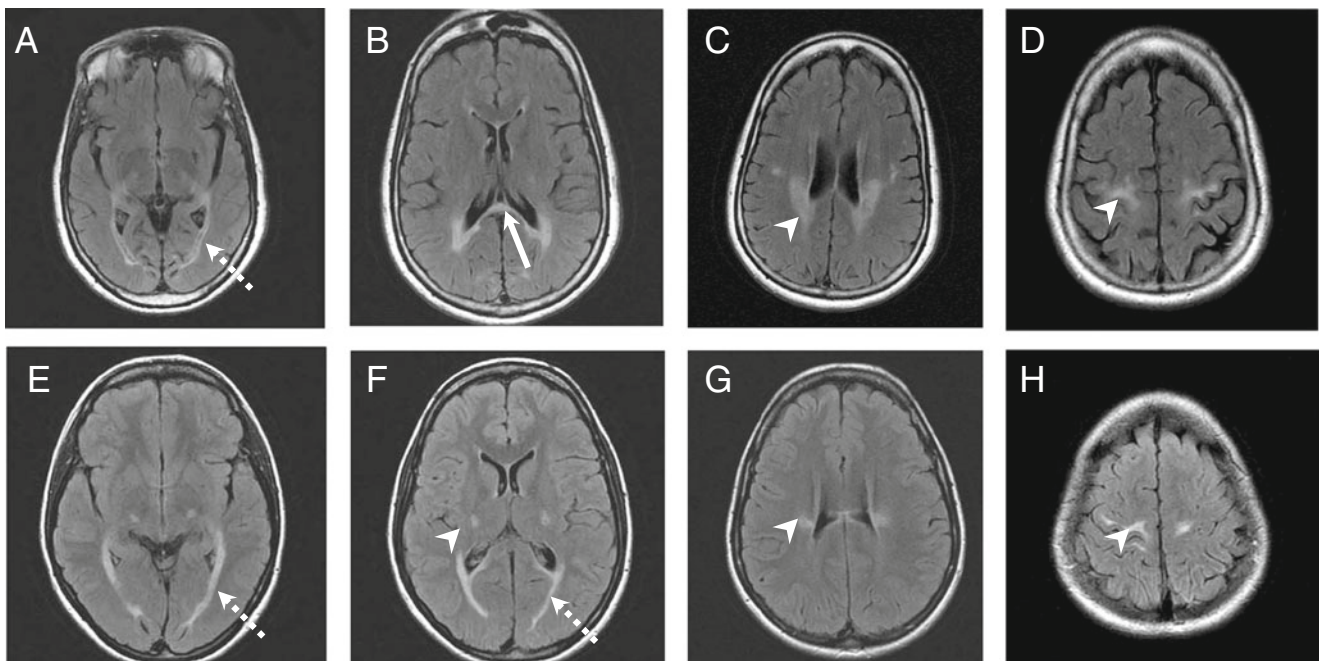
Brain MRI of patients numbered 1 (a–d) and 3 (e–h) showing the T2-Flair hyperintensities of the pyramidal tract (*arrow heads*), splenium of the corpus callosum (*white arrows*) and optic radiations (*dotted arrows*)
